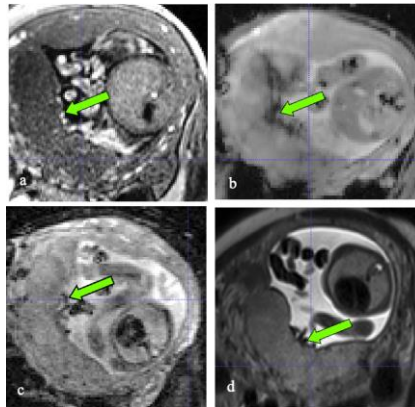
The figure shows the different MRI contrast images for a pregnancy FGR. Shown are (a) T_1 , (b) T_2^* , (c) IVIM (at $b\text{-value} = 0 \text{ s/mm}^2$), and (d) HASTE. Major blood vessels are identified by arrows. A visual difference in the appearance of the vasculature can be observed.
